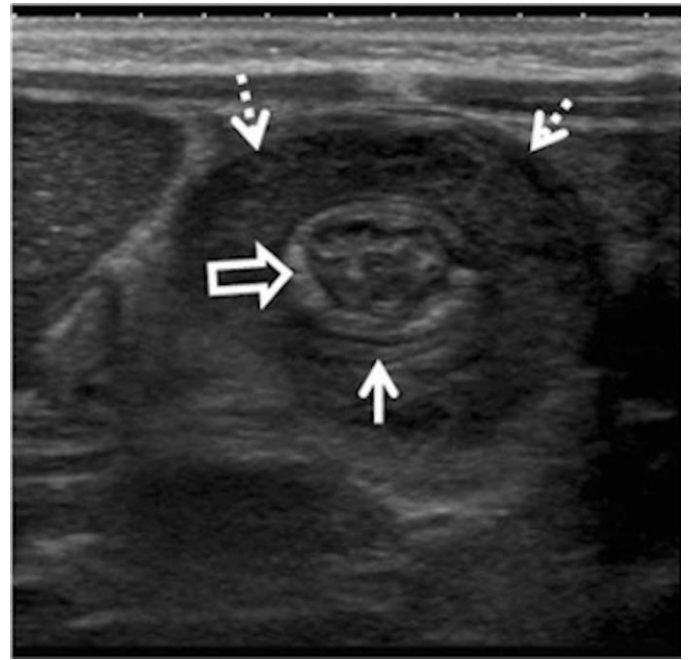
Intussusception of the appendix in a 13-month-old boy. Findings: Transverse ultrasound demonstrates ileocolic intussusception (dashed arrows) with a classic target appearance. A tubular structure suggestive of a normal appendix (solid arrow) is seen in the intussusceptum (open arrow). Technique: Ultrasound of the right lower abdomen using a 7 MHz linear array with graded compression. (Reprinted by permission: Dietz et al. Beyond acute appendicitis: imaging of additional pathologies of the pediatric appendix. *Pediatr Radiol.* 2013 Jan;43(2):232-42.)
